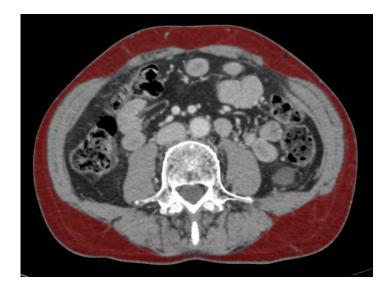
Subcutaneous Fat area measurement in CT scans.
